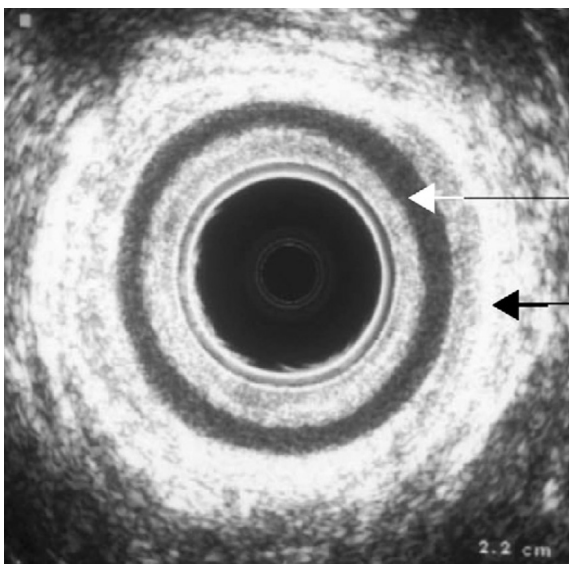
Endoluminal ultrasound scan of normal anal canal (white arrow, internal anal sphincter; black arrow, external anal sphincter).
